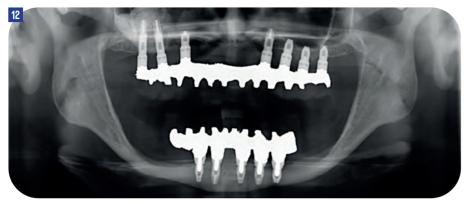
Radiograph at five-year follow-up showing stable treatment outcome
